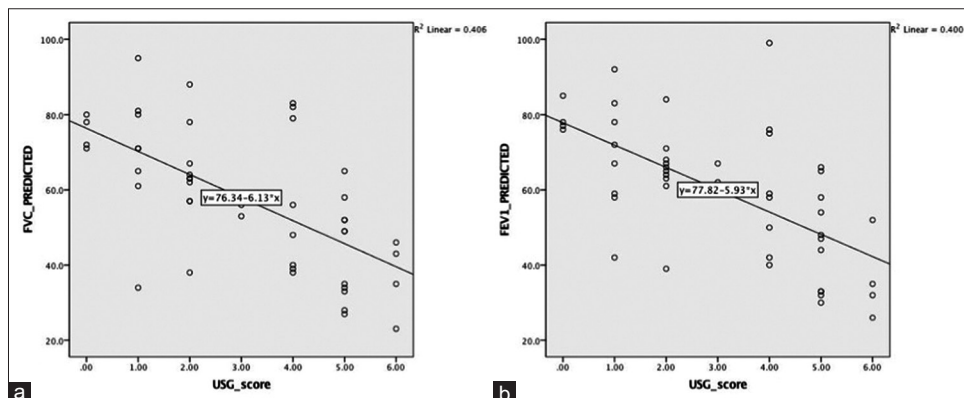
Scatter Plot showing negative correlation between lung ultrasound Score and predicted forced vital capacity (a) and predicted Forced expiratory volume in 1 s (b)
